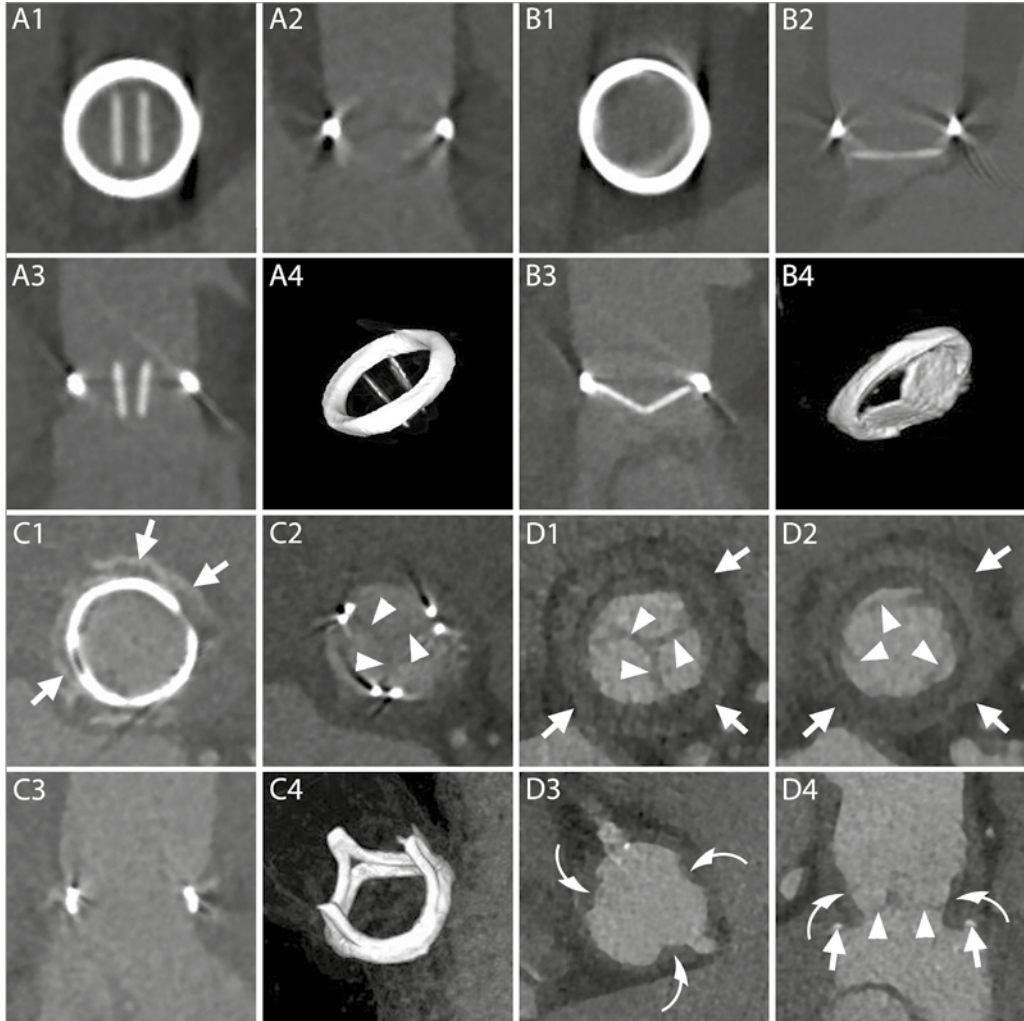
Normal aspect of prosthetic heart valves. A1-B4 – CT aspect of the most commonly employed mechanical prosthetic valve (St. Jude, Abbot). The bi-leaflet valve is shown with open and closed leaflets respectively during systole (A1-A4) and diastole (B1-B4). A1 and B1 – multiplanar reconstructions (MPR) on planes perpendicular to the centerline of the aorta at the level of the outer ring of the valve. A2 and B2 – MPR parallel to the centerline of the aorta and parallel to the direction of the leaflets. A3 and B3 – MPR parallel to the centerline of the aorta and perpendicular to the direction of the leaflets. A4 and B4 – volume rendering (VR) of the valve. C1-C4 – CT aspect of a stented biological valve during diastole. C1 and C2 – MPR on planes perpendicular to the centerline of the aorta respectively at the level of the most caudal (C1) and most cranial (C2) part of the metallic stent. In C1 the pledgets used to reinforce the sutures on the suture ring are visible
